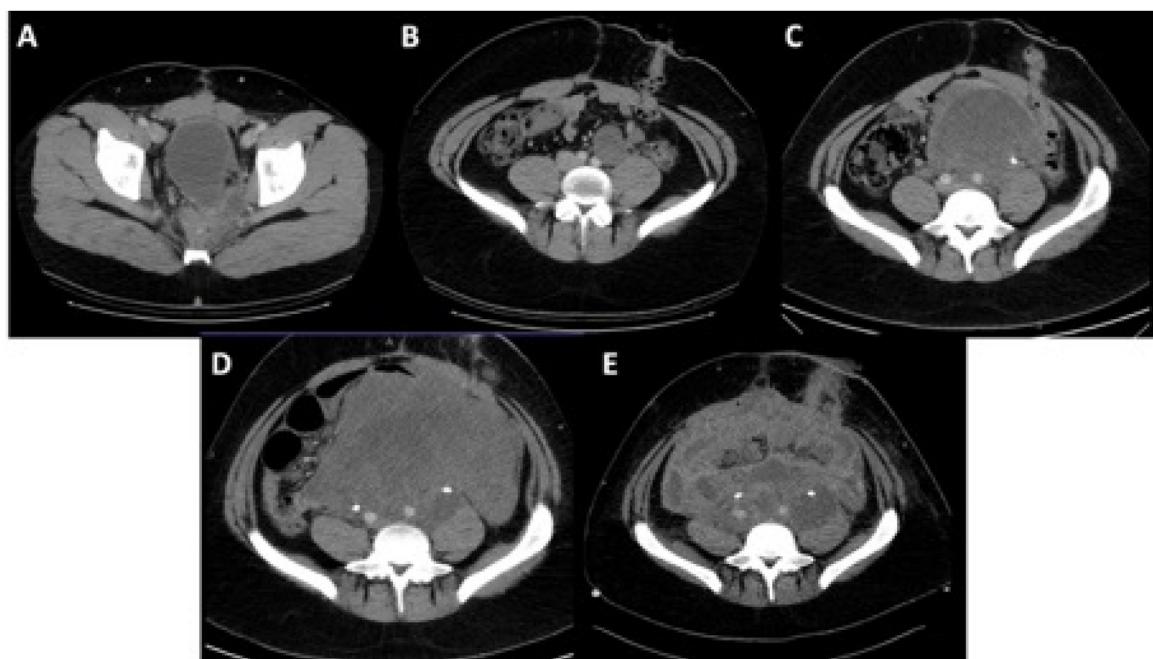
CT scan of the abdomen. A: Primary tumor near the urinary bladder. B–E showing almost same level (near stoma) at different phases of treatment. B: after initial resection. C: during radiation. D: ileus before second surgery. E: After second tumor reduction.
